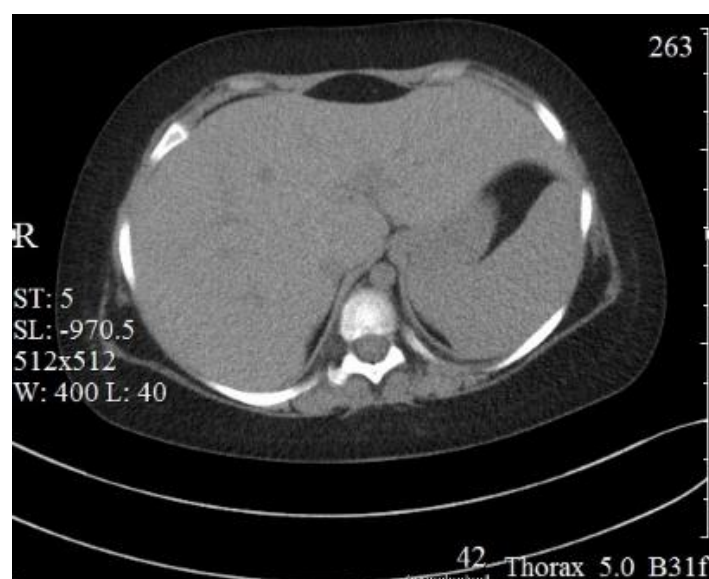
CT-scan of the abdominal organs from March 2, 2020
